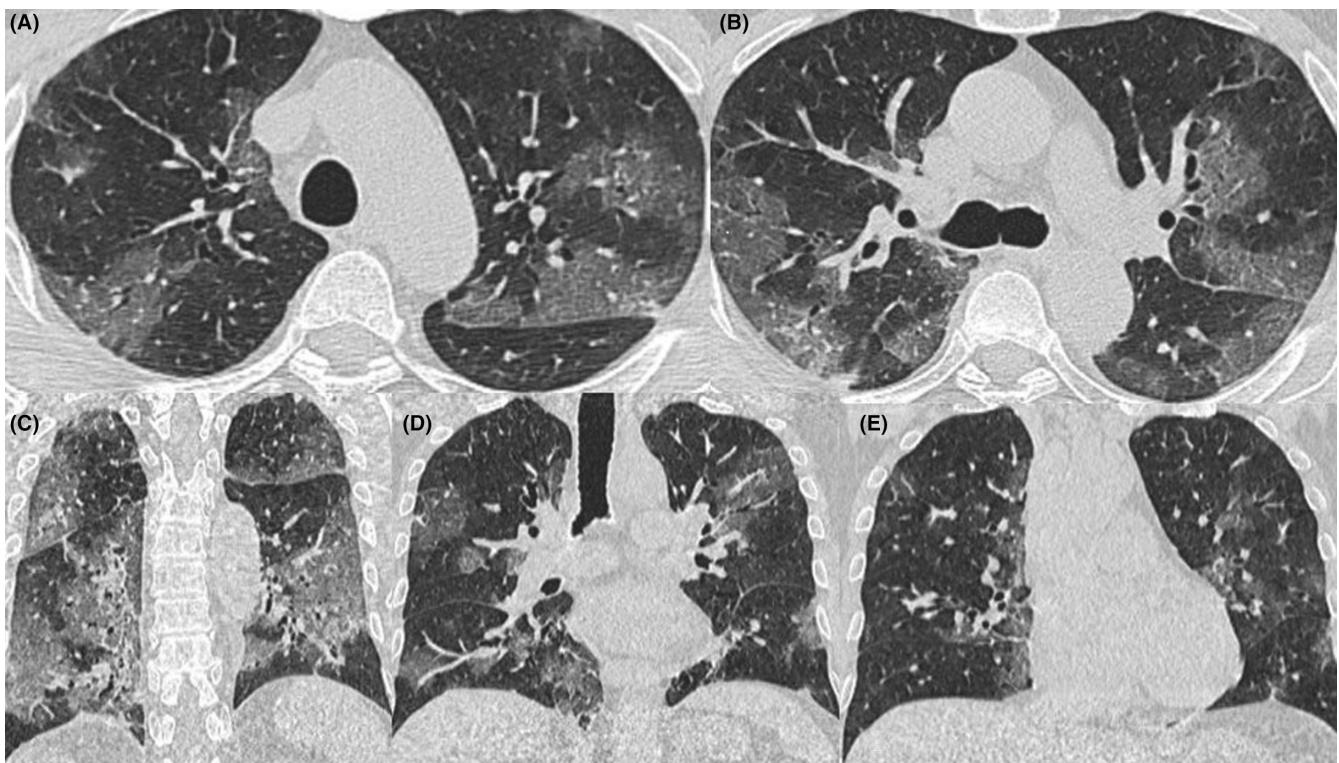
The axial (A,B) and coronal (C–E) reformatted computerized tomography (CT) images demonstrate an example of severe CT-SS. Patchy areas of ground-glass opacities were noted in several segments in both lungs. All 20 segments were scored from 0 to 2 based on the percent involvement. All scores were added to a total CT severity score of 31
